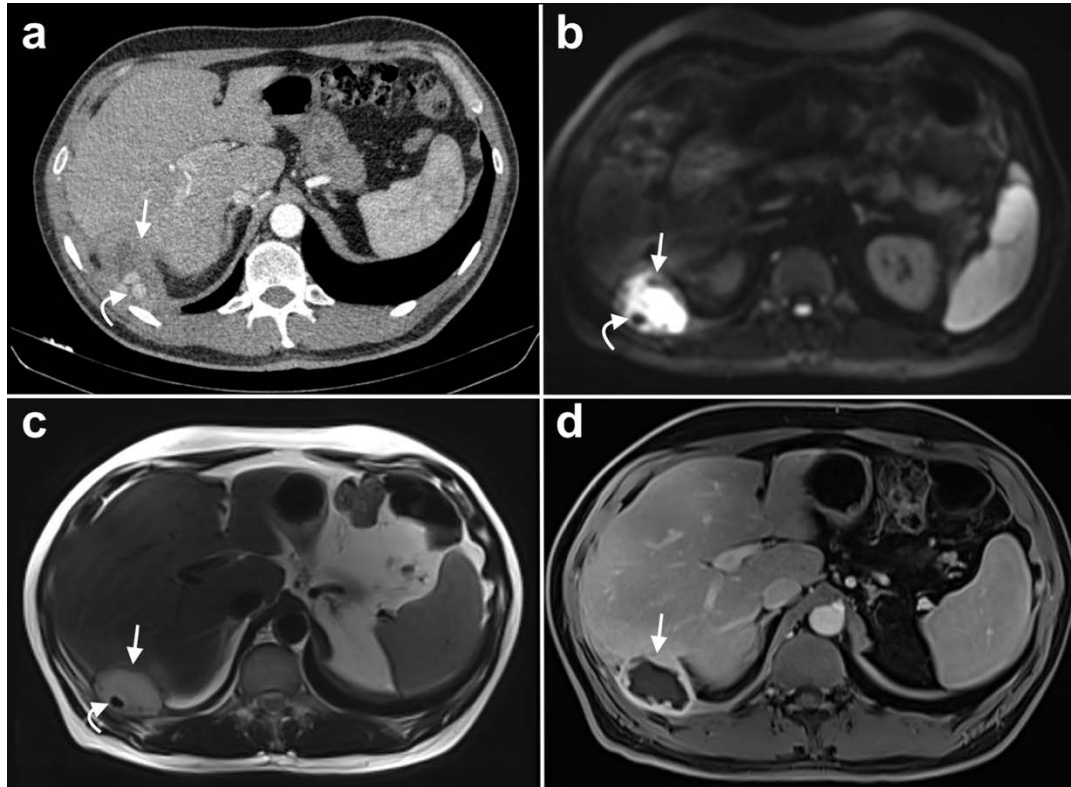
(a) Contrast-enhanced axial abdominal computed tomography image demonstrates a perihepatic fluid collection (white arrow) containing internal hyperdense foci (curved arrow) consistent with gallstones. (b) Axial diffusion-weighted magnetic resonance image (MRI) reveals restricted diffusion within the collection (white arrow) and internal hypointense nodularity (curved arrow) compatible with gallstones. (c) Axial T2-weighted MRI shows a hyperintense collection with internal hypointense nodularity (curved arrow) representing gallstones. (d) Axial post-contrast T1-weighted MRI demonstrates a collection with marked peripheral enhancement (white arrow).
